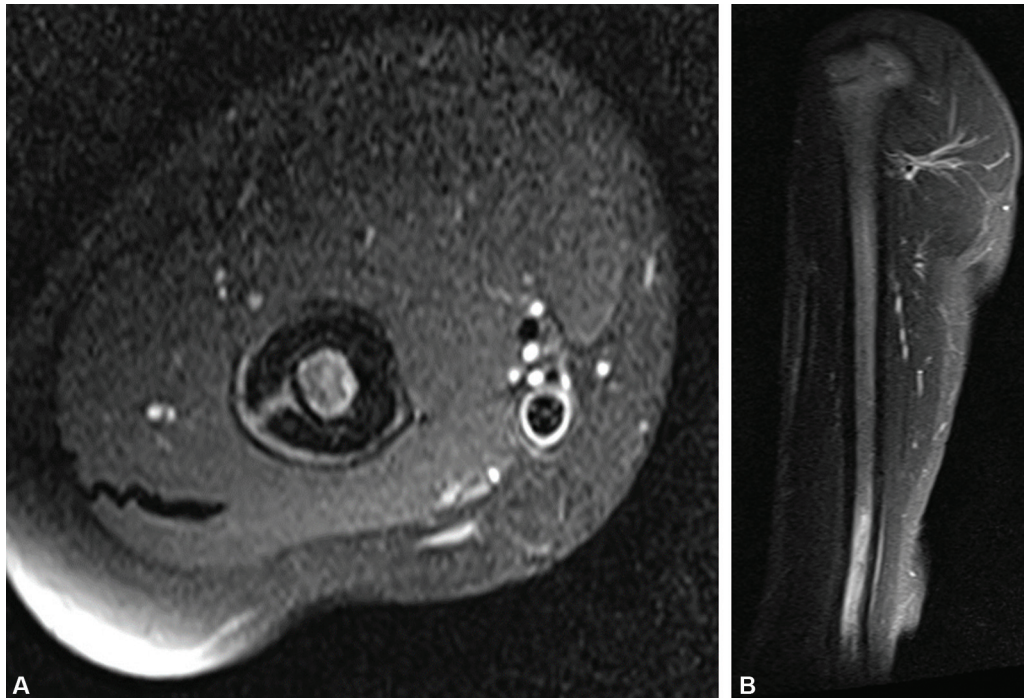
Axial, fat-suppressed proton density-weighted (A) and STIR sagittal (B) magnetic resonance imaging depicting maintenance of posterior cortex thickening, linear fracture line and slight reduction in periosteal and endosteal edema.
